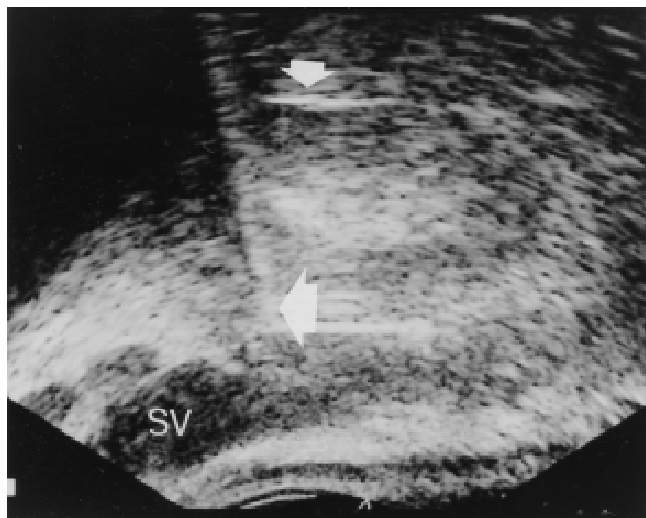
Longitudinal (sagittal) display of transrectal ultrasonography (TRUS) during placement of guidewires into the prostate. One wire is seen anterior to the seminal vesicle (SV) with acoustic reverberation from its proximal tip (large arrow). A second wire previously placed more anteriorly is seen at the prostatovesical junction (small arrow).
